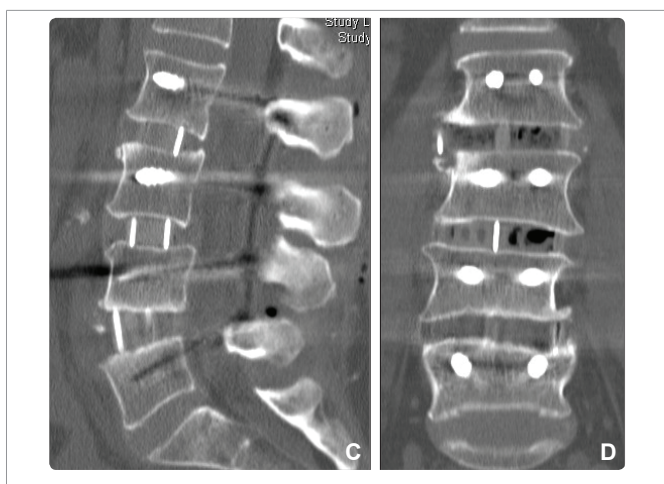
Postoperative CT-scan reconstructions in sagittal and coronal planes showing the enlargement of the spinal canal in the operated segments and restoration of lumbar lordosis with normalization of sagittal balance. Note the size of the intervertebral PEEK cages in the coronal plane, reaching from one lateral apophyseal ring of the respective vertebral body to the other.
